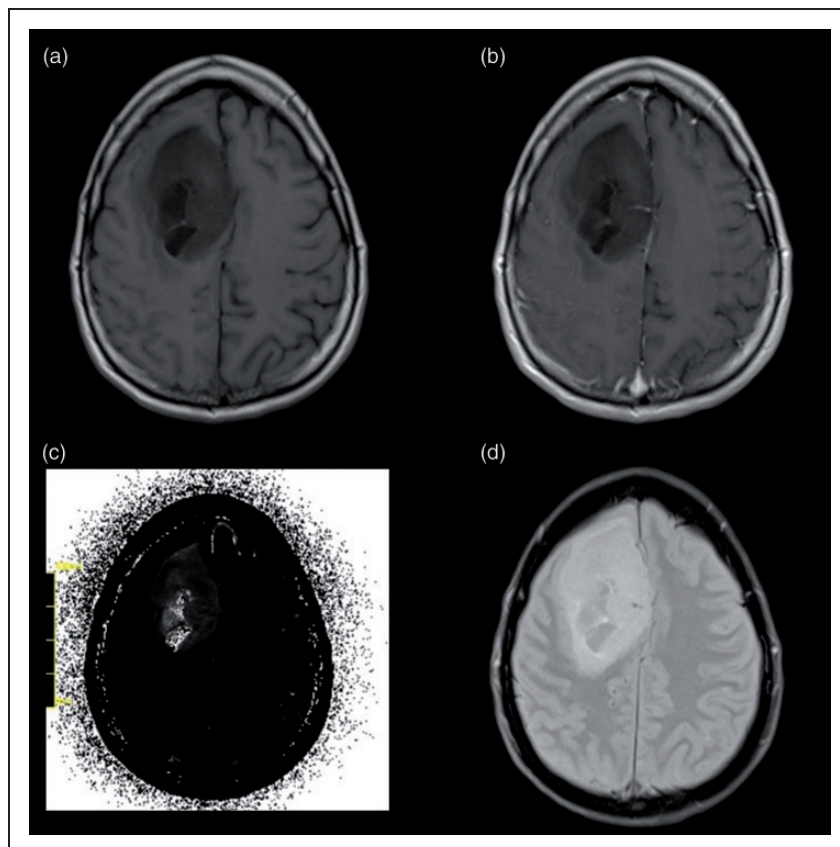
Patient, 49 years old, with a heterogenous IDHm grade III glioma located in the right frontal region (a) and without a significant positive CE in the T1CE sequences (b). (c) Shows the original raw T2 Map while (d) shows the corresponding FLAIR-sequence without a large oedema.
